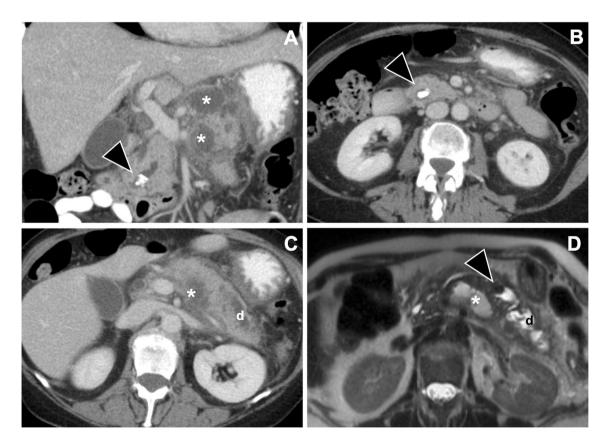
61-year-old female with recent recurrent bout of pancreatitis. a and b The contrast-enhanced CT scan reveals a 9 mm calcified stone (arrow head) in the pre-ampullary region of the main pancreatic duct with short segment dilation of the upstream main pancreatic duct segment. Signs of acute pancreatitis are present, such as peripancreatic fluid collections surrounding the pancreatic body and tail (*) and blurring of the peripancreatic fat planes with streaky soft tissue
